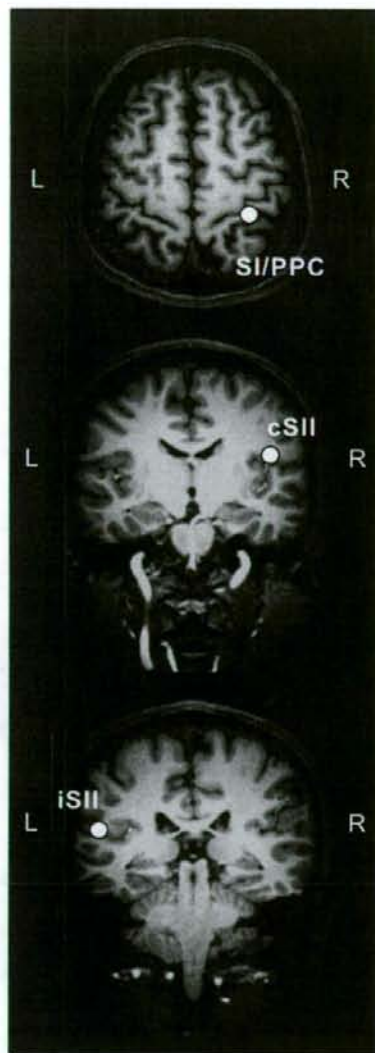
Location of ECDs superimposed on a 2D MRI scan in a representative subject. L=left, R=right, SI=primary somatosensory cortex, PPC=posterior parietal cortex, cSII=secondary somatosensory cortex contralateral to the stimulation, iSII=secondary somatosensory cortex ipsilateral to the stimulation.
